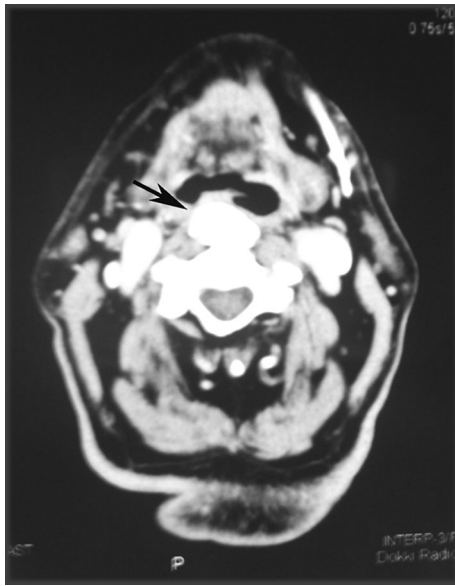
An axial computed tomography. The *arrow* points to a large osteophyte compressing the posterior pharyngeal wall
